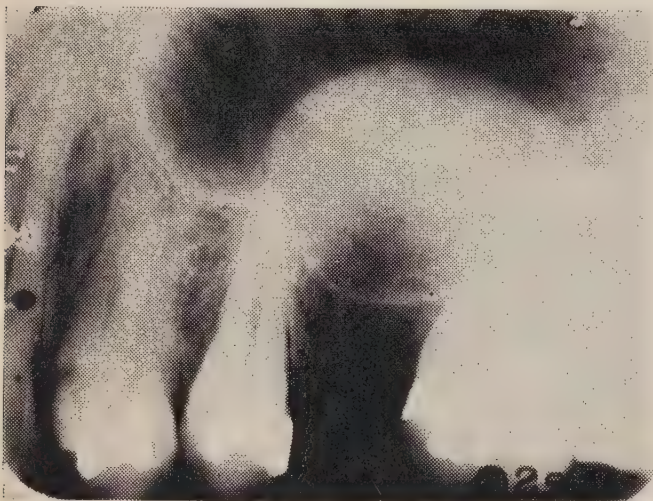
Periapical radiograph showing a mass in the base of the maxillary sinus. This is a mucous retention cyst.
